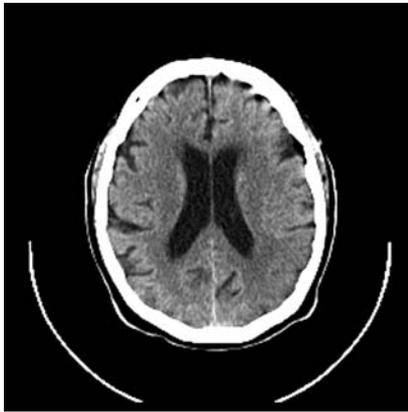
Computed tomography of the brain at the time of admission, which was interpreted as normal.
